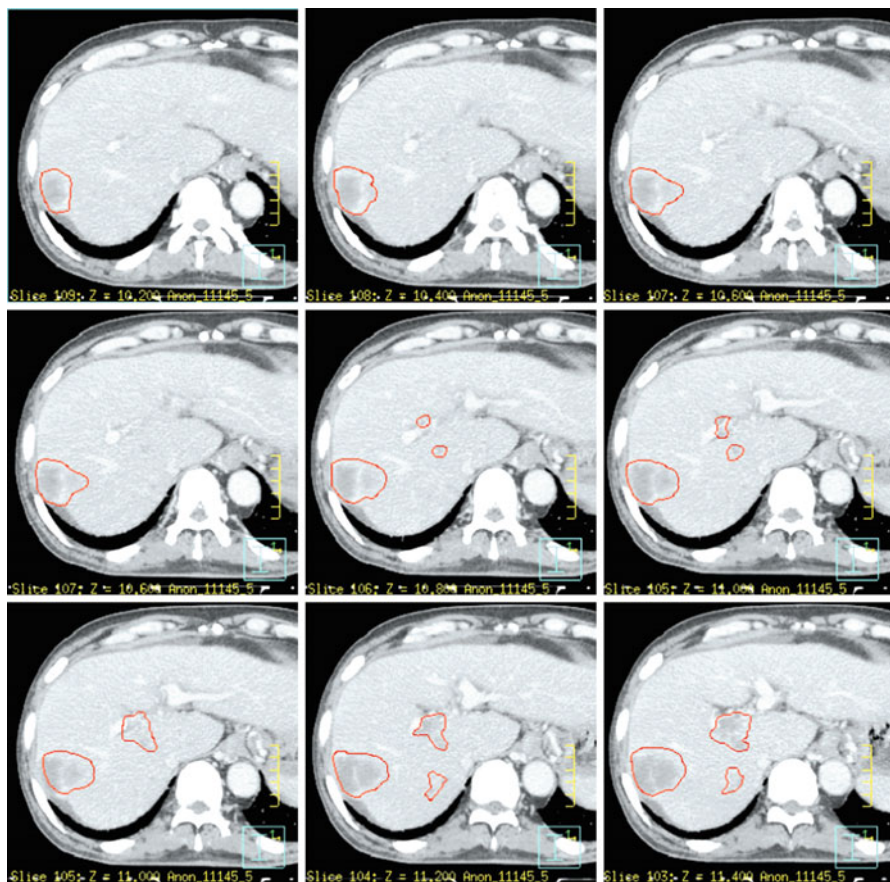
HCC with extensive tumor thrombus (*red contours*), best seen on venous phase CT
